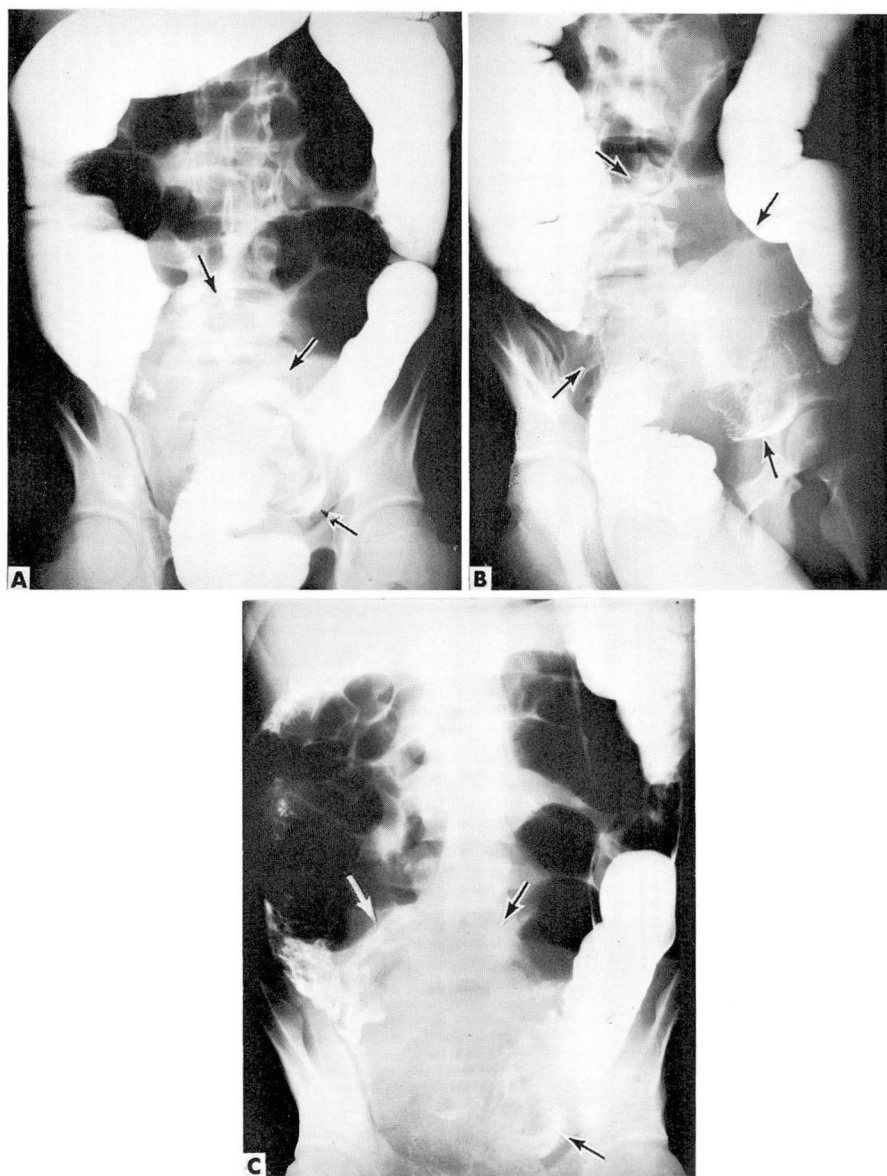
Roentgenogram of the abdomen after barium enema, showing pelvic mass with extrinsic pressure on the sigmoid colon and irregularity of the cecum.
